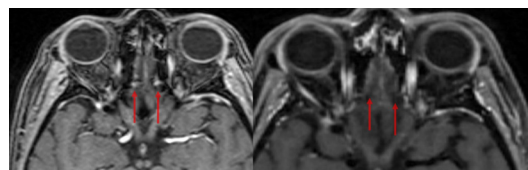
Mild olfactory enhancement noted on initial MRI, resolved on follow-up.
